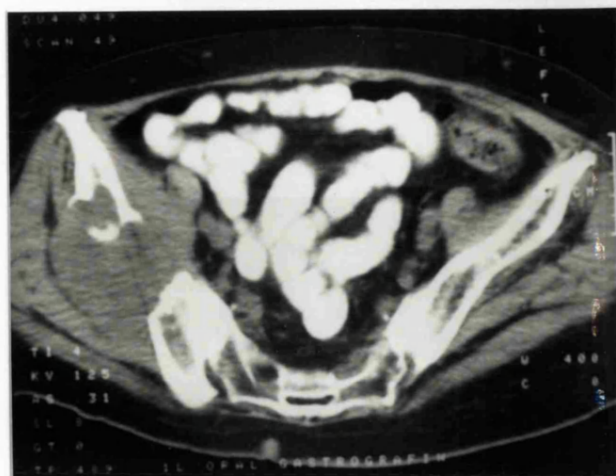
CT scan showing expanding lesion in right hemi-pelvis.
